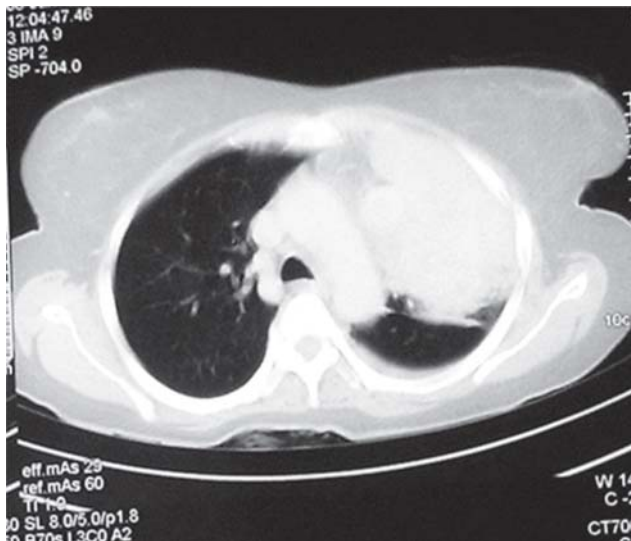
Computed tomography of chest (lung window) showing a mass lesion in the left upper lobe with the absence of air bronchogram and normal contralateral lung.
